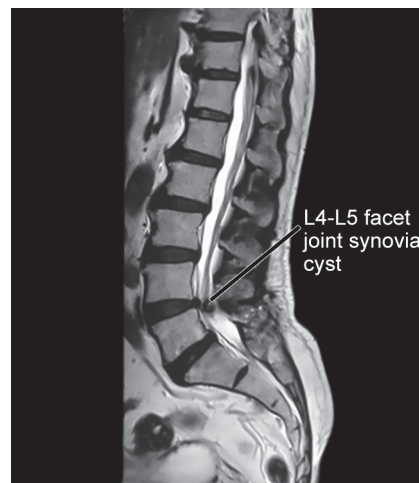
Sagittal MRI section depicting synovial cyst at L4-L5 level
